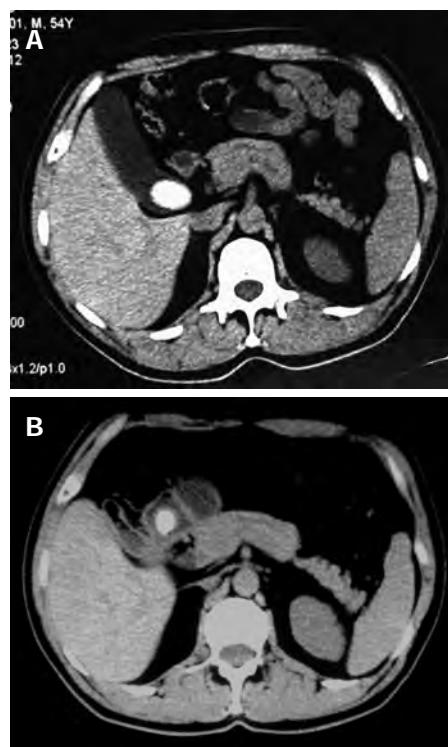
Abdominal computed tomography. A: Revealing a large calcified mass in the gallbladder (one year prior); B: Indicating the migration of the large stone from the gallbladder to the pylorus and gas shadows seen in the gallbladder (this time).
